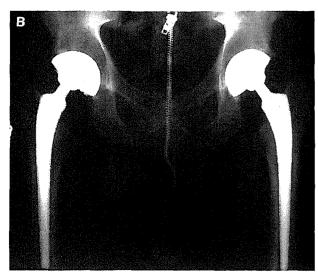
(A) Immediate postoperative radiograph of a 51year-old male patient who presented with bilateral osteoarthritis of both hips and status post left total knee arthroplasty performed 5 years previously. The radiograph reveals treatment consisting of bilateral cementless total hip arthroplasty using a Mallory-Head Porous femoral component (Biomet, Inc., Warsaw, IN) in both hips, a Mallory-Head Radial acetabular component (Biomet, Inc.) with the M²a-taper metal-on-metal articulation on the left side, and a Mallory-Head Solid Porous acetabular component (Biomet, Inc.) with an ArCom polyethylene liner (Biomet, Inc.) on the right side. (B) Radiograph at 5-year postoperative follow-up reveals similar features of excellent fixation and components in satisfactory position and alignment, with identical Harris hip scores of 96 points for each side.
